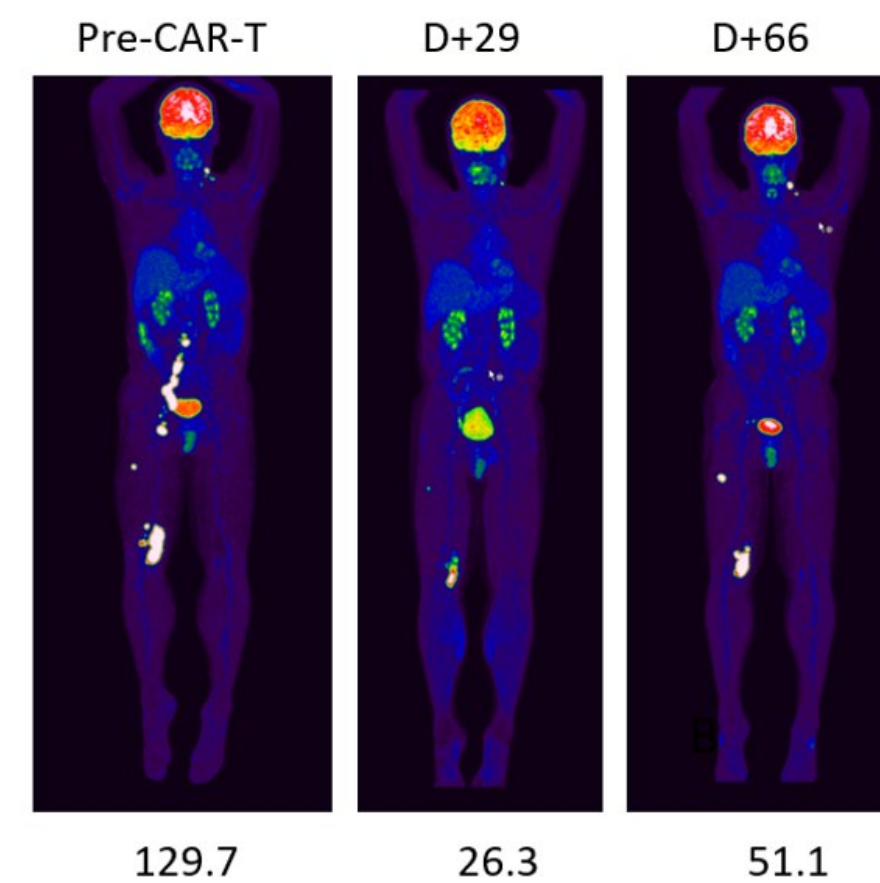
PET images demonstrating tumor metabolic activity as well metabolic tumor volume (MTV) quantitation based on PET/CT measurements prior to CAR-T, at D+29 and D+66
